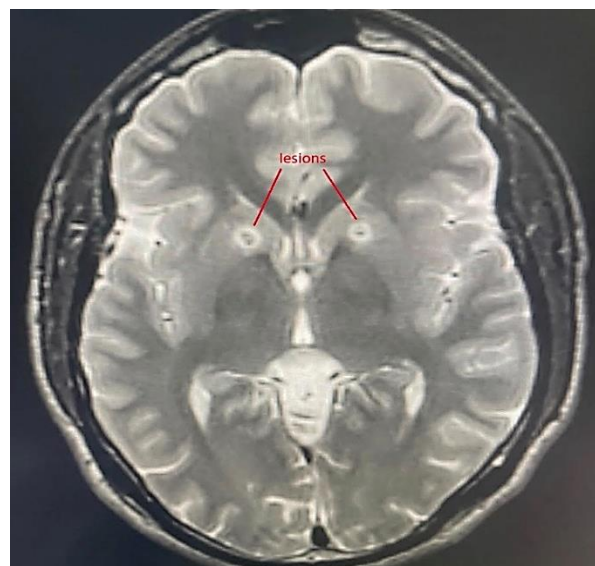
Post-operative T2-magnetic resonance imaging (MRI)
